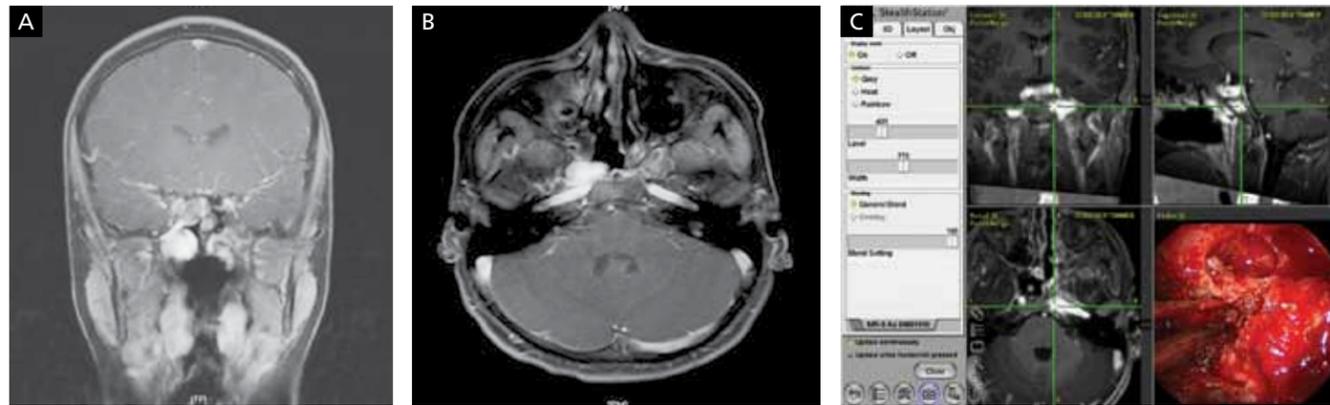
(A) Coronal and (B) axial T1-weighted contrast magnetic resonance images in a 12-year-old with a recurrent juvenile angiofibroma presenting with a local recurrence, previously treated with midface degloving. Following endoscopic medial maxillectomy and inferior turbinectomy, (C) the tumor was resected off the inferior clivus and floor of the sphenoid sinus.
